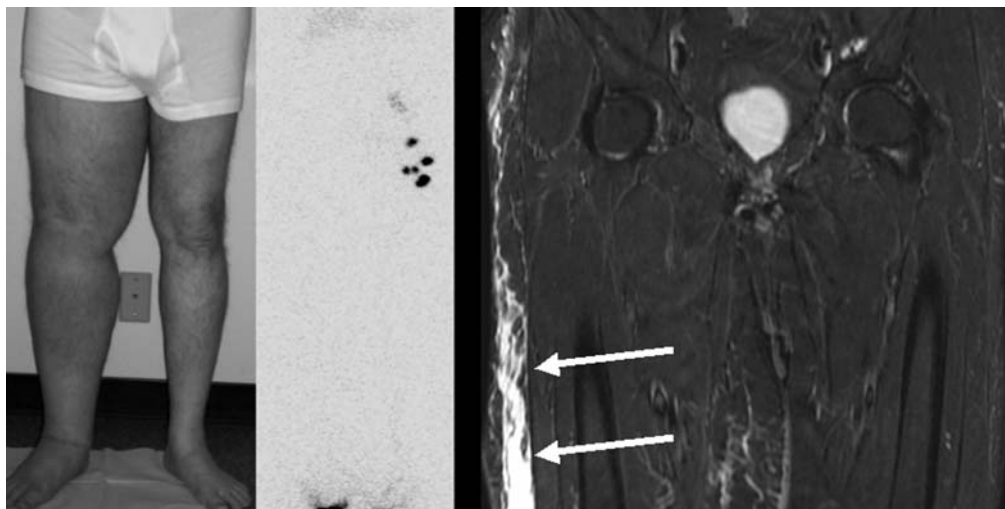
Secondary LE after surgery for bladder cancer. *Middle Panel:* Lymphoscintigram demonstrates no lymphatic flow in edematous right leg 2 hours after injection in both feet, with normal migration to left inguinal nodes. *Right Panel:* Fat-suppressed magnetic resonance image demonstrates edema in epifascial compartment (arrows).
